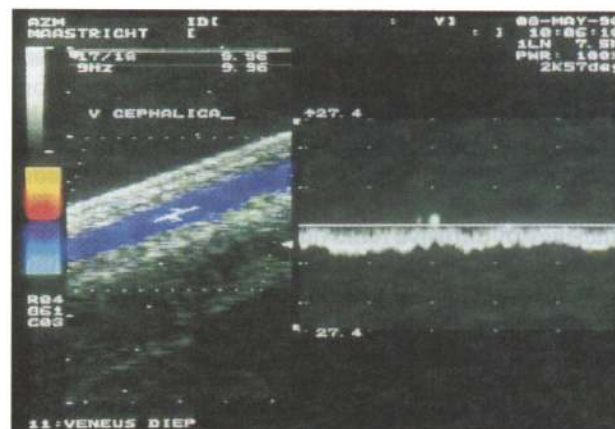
Colour Duplex scan of the cephalic vein in the forearm. The B-mode image (left-hand scan) shows the vein, and the Doppler spectrum is obtained from the same vein (right-hand site).
